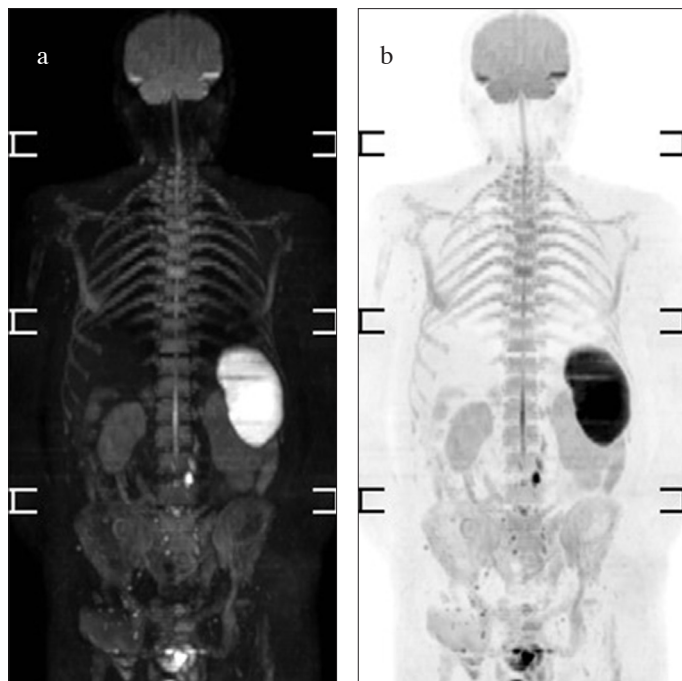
a, b. Whole-body biparametric magnetic resonance imaging at 1.5T in a 33-year-old man after orchiectomy for nonseminomatous germ cell tumor. Enlarged left retroperitoneal lymph node is detected on diffusion-weighted imaging (DWI) with high b-values (a) and DWI with high b-values inverted (b). Unenhanced chest computed tomography is performed to detect lung nodules
